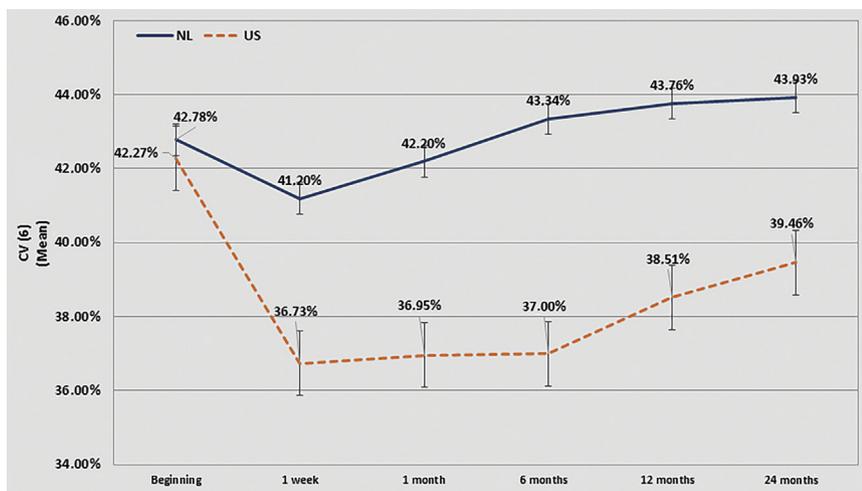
The mean CoV of hexagonal cells over a 24-month period ($P < .001$) (CV = coefficient of variation; NL = nanosecond laser; US = ultrasound).
